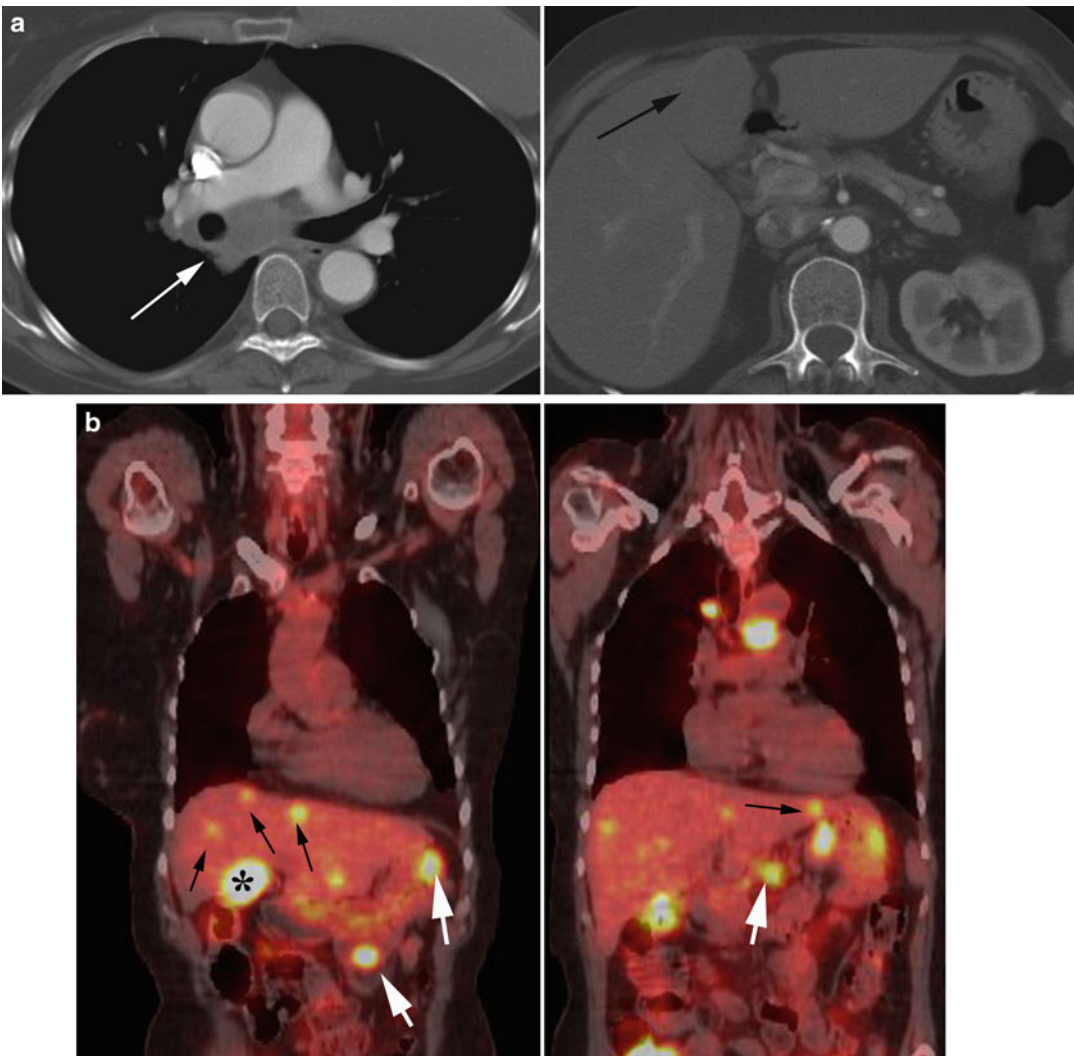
Value of FDG-PET/CT in assessing extent of disease. (a) Axial CT images reveal mediastinal adenopathy and solitary hepatic metastasis (arrows) as the only sites of disease on conventional staging. (b) Coronal FDG-PET/CT images confirm the adenopathy and liver
